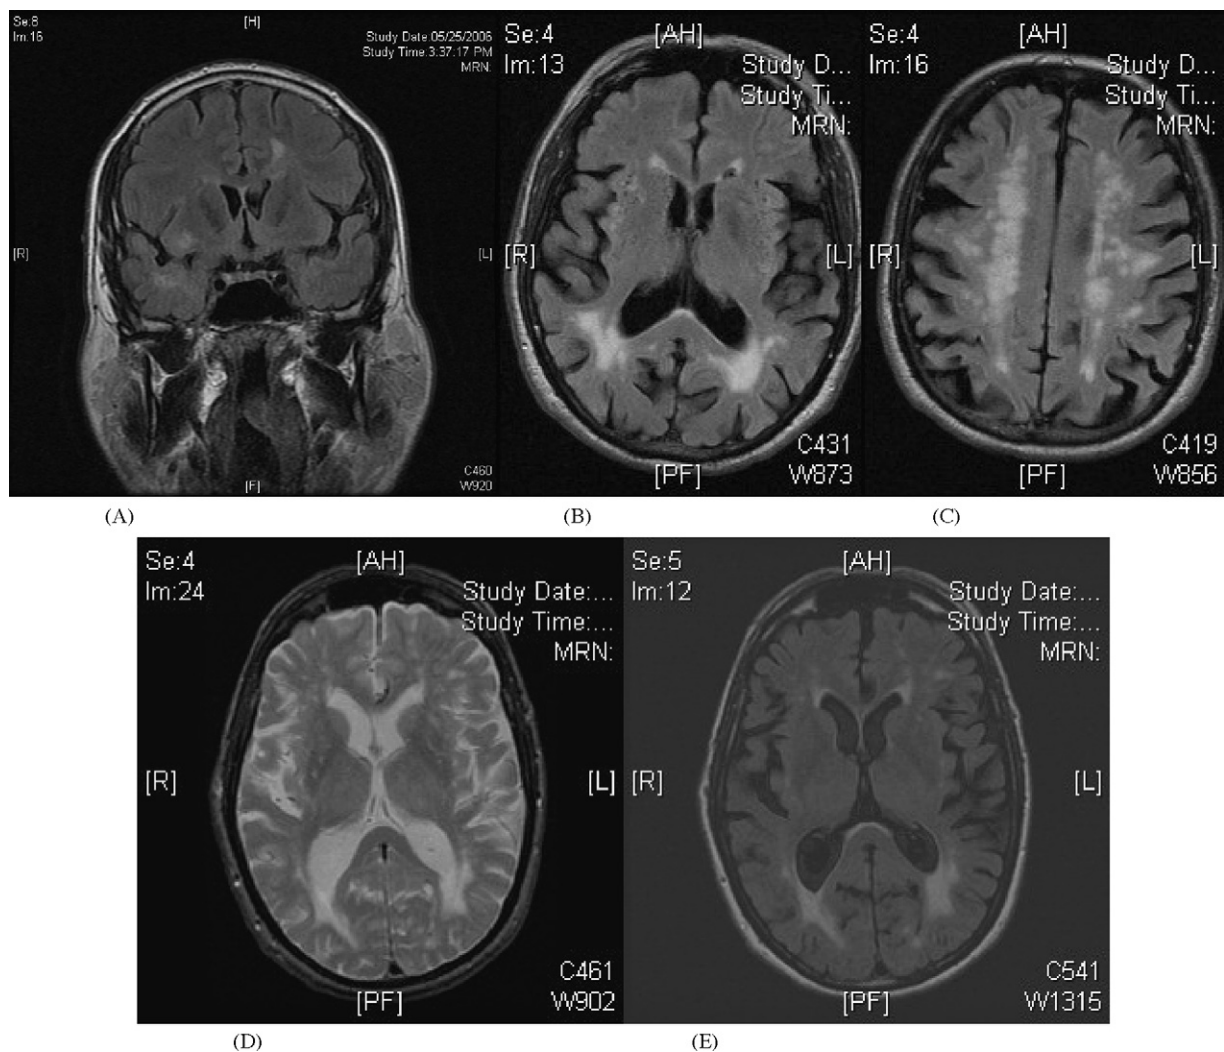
Brain MRI scans. (A) Flair sequence, MZ patient with demyelinating disease post-immunization with abnormal areas next to corpus callosum—left hemisphere and in right temporal lobe. (B) Flair sequence MZ patient with confluent white matter lesions in posterior white matter and (C) multiple other lesions throughout deep white matter in same patient as (B). Another MZ patient with severe white matter lesions visualized on T2 imaging (D) and Flair sequences (E).
